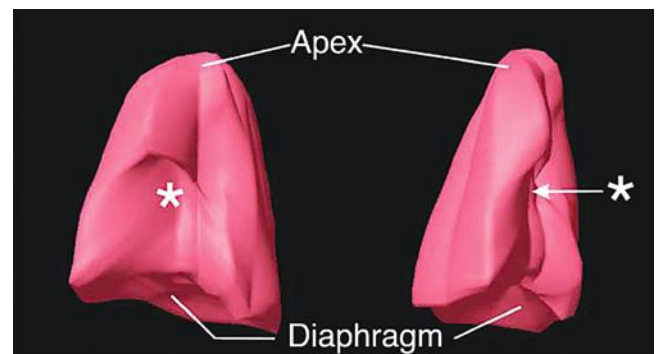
Three-dimensional ultrasound model of the right lung volume obtained using VOCAL. Note the indentation of the fetal heart (*asterisk*). The frontal view is shown on the left and the lateral view on the right. (From Kalache KD, Espinoza J, Chaiworapongsa T, et al: Three-dimensional ultrasound fetal lung volume measurement: a systematic study comparing the multiplanar method with the rotational (VOCAL) technique. *Ultrasound Obstet Gynecol* 21;111, 2003.)
